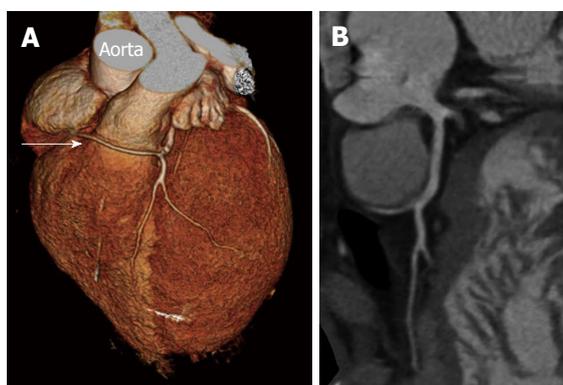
Single coronary artery. A: Three-dimensional volume-rendered image of benign course of right coronary artery (arrow) from left sinus of Valsalva (Lipton L-IIA); B: Transverse multi-slice computed tomography scan in subtype (Lipton L-IIA) demonstrating the origin of the single coronary artery arising from the left sinus of Valsalva supplying the whole heart.
